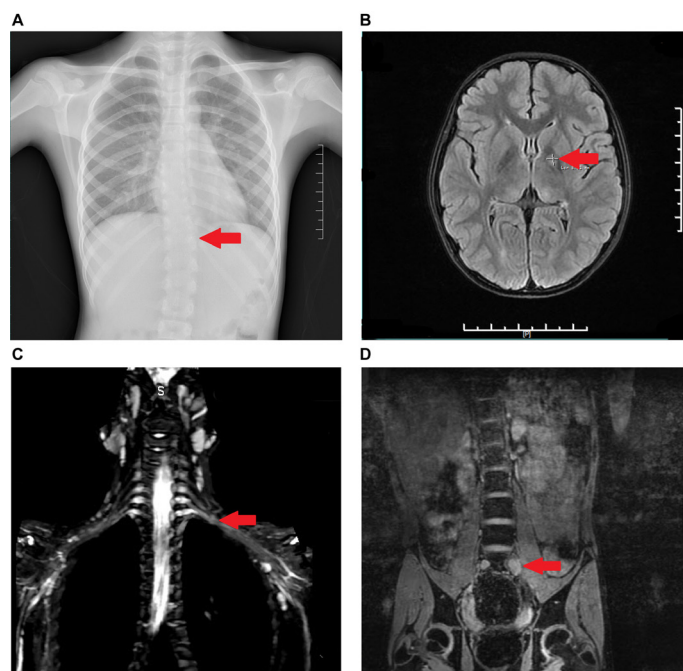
A) Chest radiograph showing thoracolumbar scoliosis. Magnetic resonance imaging of brain and spinal cord. B) Abnormal nodular signals in bilateral basal ganglia-thalamus region. C) Slight thickening of C8 (the left brachial plexus nerve). D) Slight thickening of the anterior branch of the fifth left lumbar nerve
